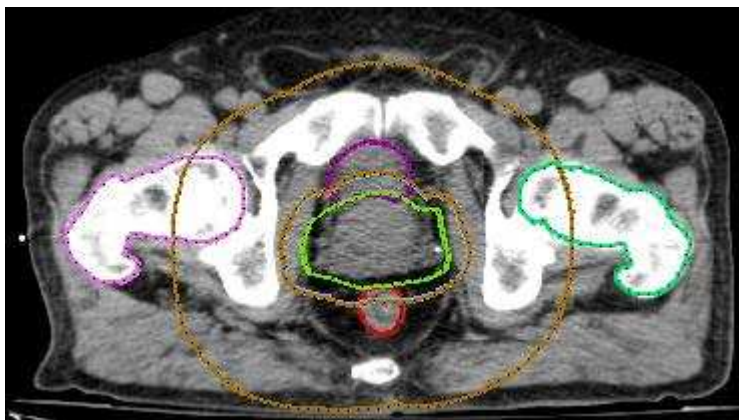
CT scan of patient displayed by CERR [15].
